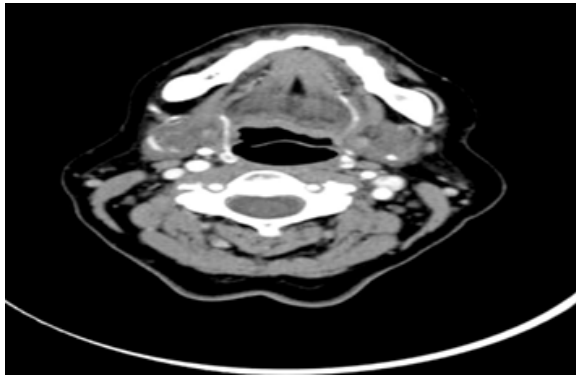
CT image showing left vocal cord involvement
